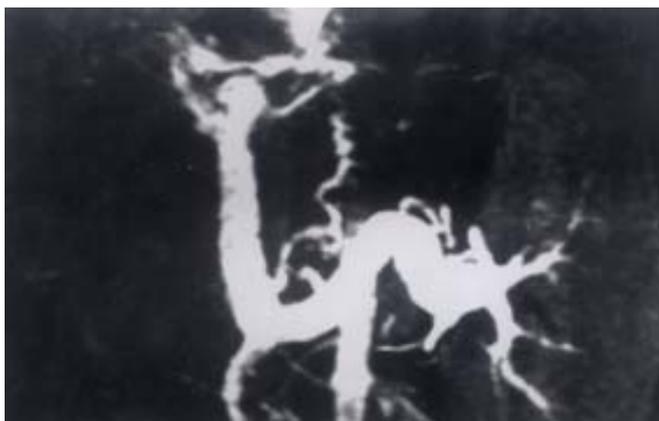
CTA of portal vein that show tributary of splenic vein clearly.
